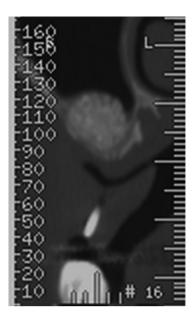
Post-op CT scan, test side.
